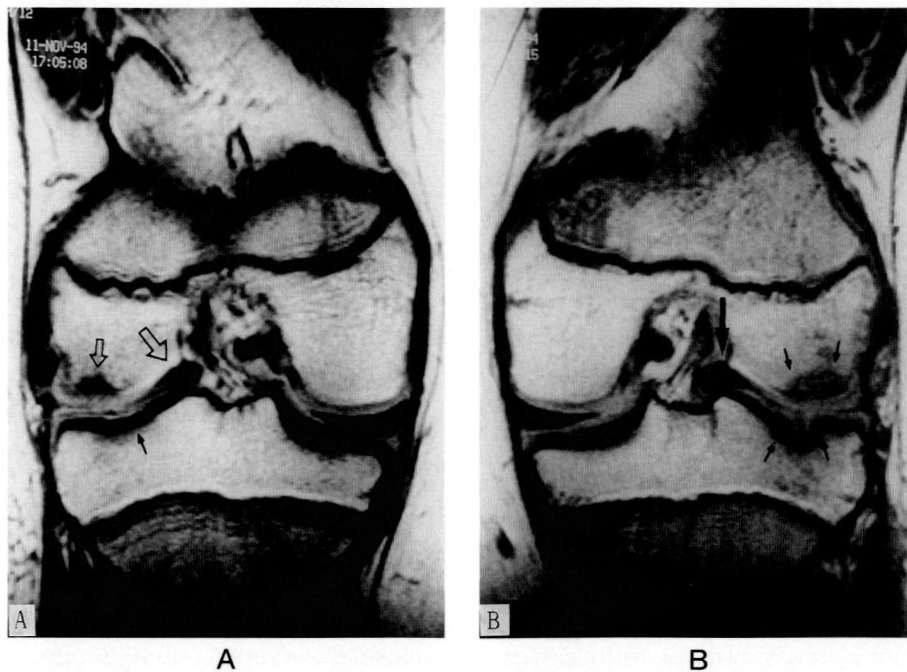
A & B. Focal and decreased signal intensities of the weight-bearing surfaces of the lateral femoral and tibial condyles of both knee and displacement of the torn lateral discoid menisci on MRI finding.
